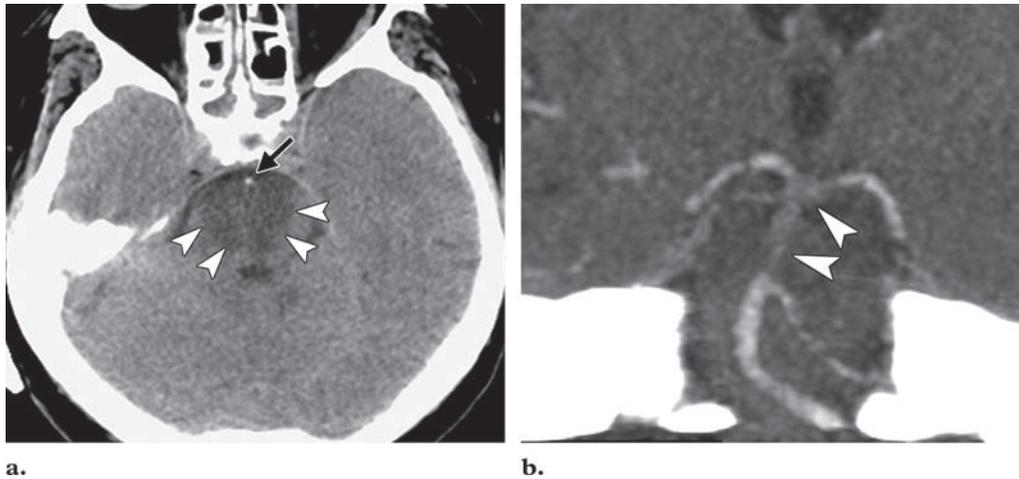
Acute stroke in a 43-year-old woman who had lost consciousness. Findings at initial nonenhanced CT were normal, and CT angiography was not performed. (a) Follow-up non-enhanced CT scan (36 hours evolution) shows a hypoattenuating midbrain (arrowheads) and a hyperattenuating basilar artery (arrow). (b) CT angiogram helps confirm a filling defect of the basilar artery (arrowheads) related to pons infarction and basilar artery obstruction.
